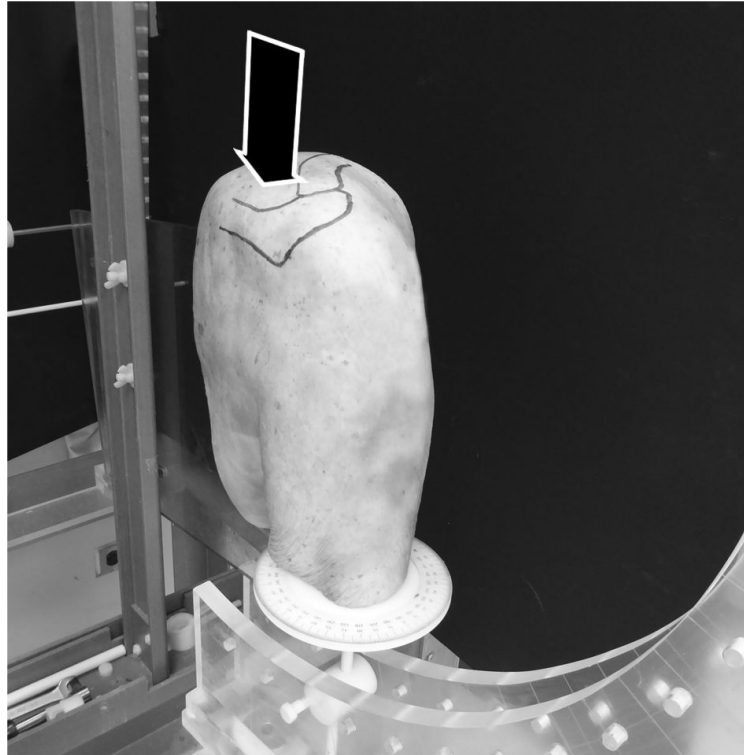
A custom-made fixture device was used to secure the scapula and a fiber glass rod inserted into the humeral medullary canal to position the humerus. Black arrow indicates the placement of the ultrasound transducer corresponding to the belly of the SSP muscle.
